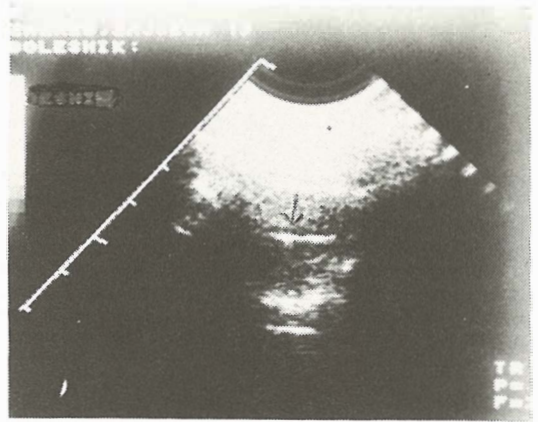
Ultrasound finding: maxillary sinus of the same patient, with fluid level
